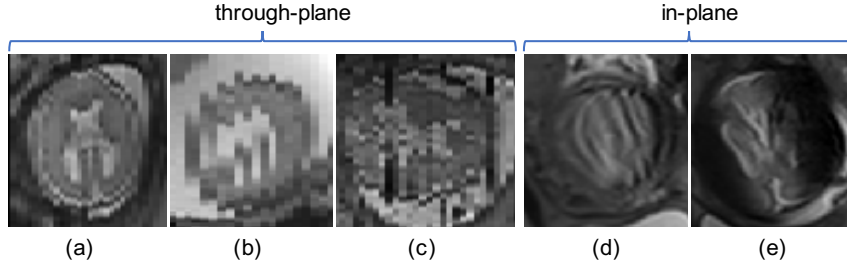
Three example stacks of fetal brain MRI. (a) has a consistent appearance and small inter-slice motion. (b) has an inconsistent motion between two interleaved sub-stacks. (c) has two outlier slices shown in (d) and (e). The gestational age is 24 weeks for the fetuses shown in (a) and (b), and 29 weeks for the fetus shown in (c)-(e).
